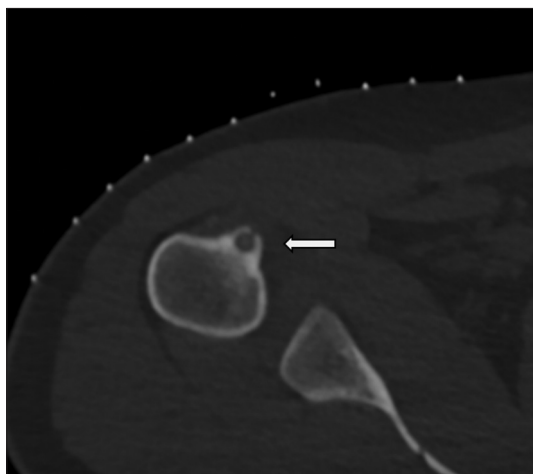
Axial CT of the right shoulder demonstrating a small 7-mm well-defined round lucent nidus within the anterior cortex of the proximal humeral shaft (arrow) with surrounding periosteal sclerosis and thickening of the anterior cortex. A small central calcification is seen within the nidus. CT – Computed tomography
